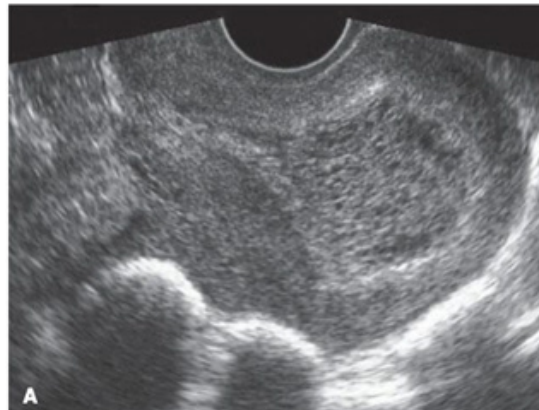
Ultrasound of Snow flake pattern.<sup>5</sup>
